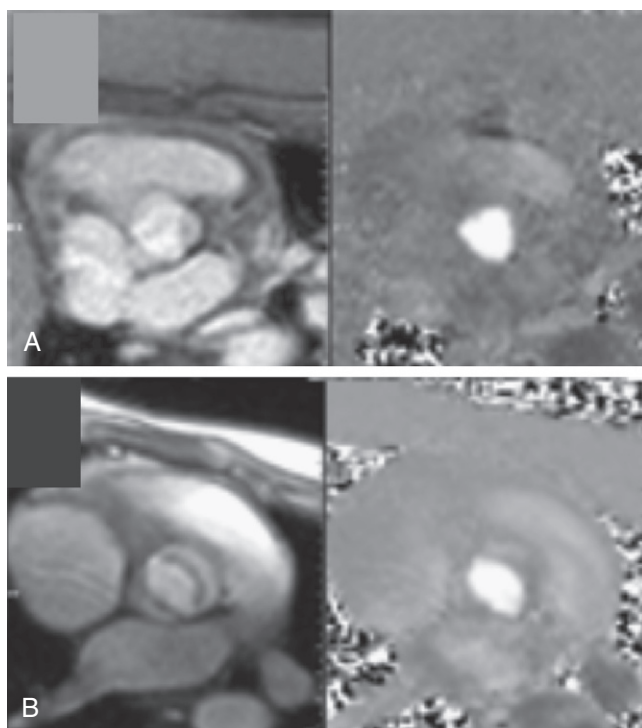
Aortic valve structure shown by cardiac magnetic resonance imaging (MRI). Anatomy is shown on the left and blood flow on the right side of each panel. Cardiac MRI is able to visualize the aortic valve more consistently than transthoracic cardiac echo. This figure shows normal tricuspid (A) and bicuspid (B) aortic valves.
